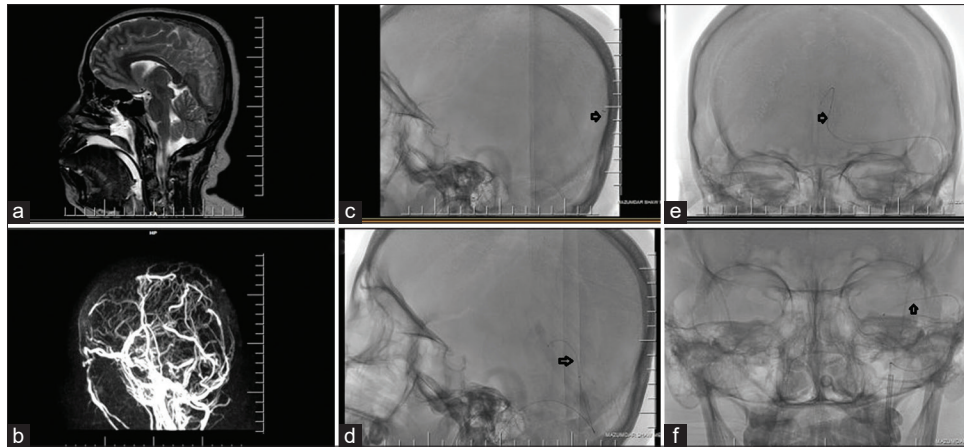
(a and b) Representational images- MRI T2 sagittal and MRV show extensive thrombus in the superior sagittal sinus, deep sinuses, and bilateral transverse sinus. (c) X-ray skull lateral projection shows aspiration catheter in the superior sagittal sinus. (d) Microcatheter in the straight sinus for *in situ* thrombolysis. (e) Microcatheter in the superior sagittal sinus for *in situ* thrombolysis. (f) Long sheath in IJV and microcatheter in the left transverse sinus for *in situ* thrombolysis. MRI = magnetic resonance imaging, MRV = magnetic resonance venography, IJV = Internal jugular vein
